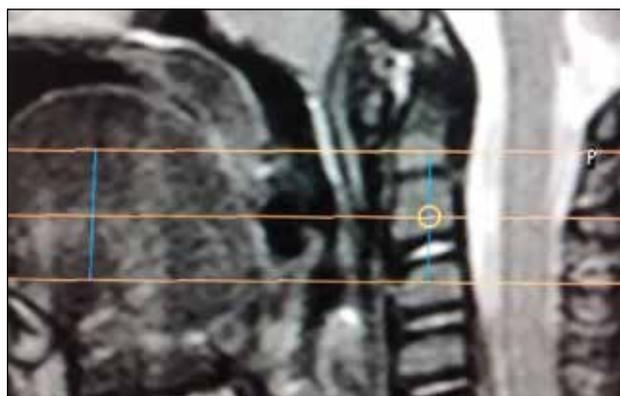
Sagittal view of MRI of the upper airway showing three levels of image acquisition at soft palate, base of the tongue and mid-level of epiglottis during dexmedetomidine infusion
